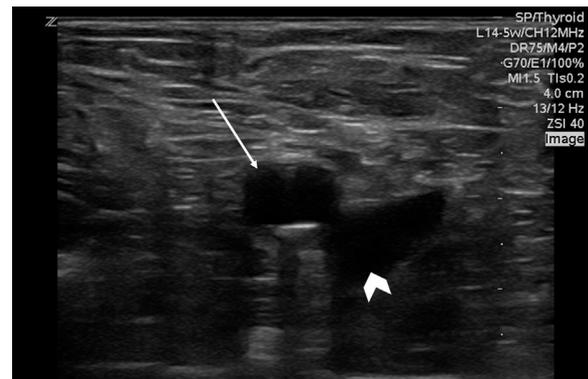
Point-of-care ultrasound of the right femoral artery of a patient with no palpable pulses demonstrating a pulsatile, non-compressible vessel (arrow). The arrowhead indicates the femoral vein.
